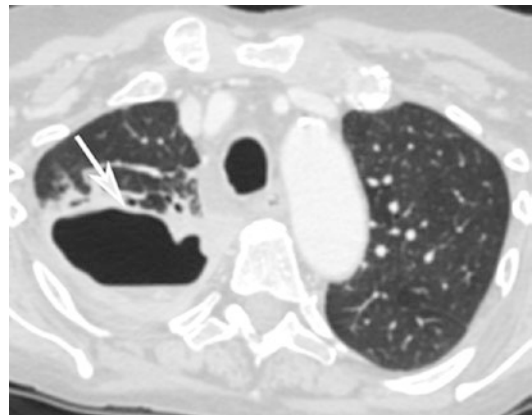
CT axial scan of the chest demonstrates a large right upper pulmonary lobe abscess with a typical air-fluid level (*arrow*)
